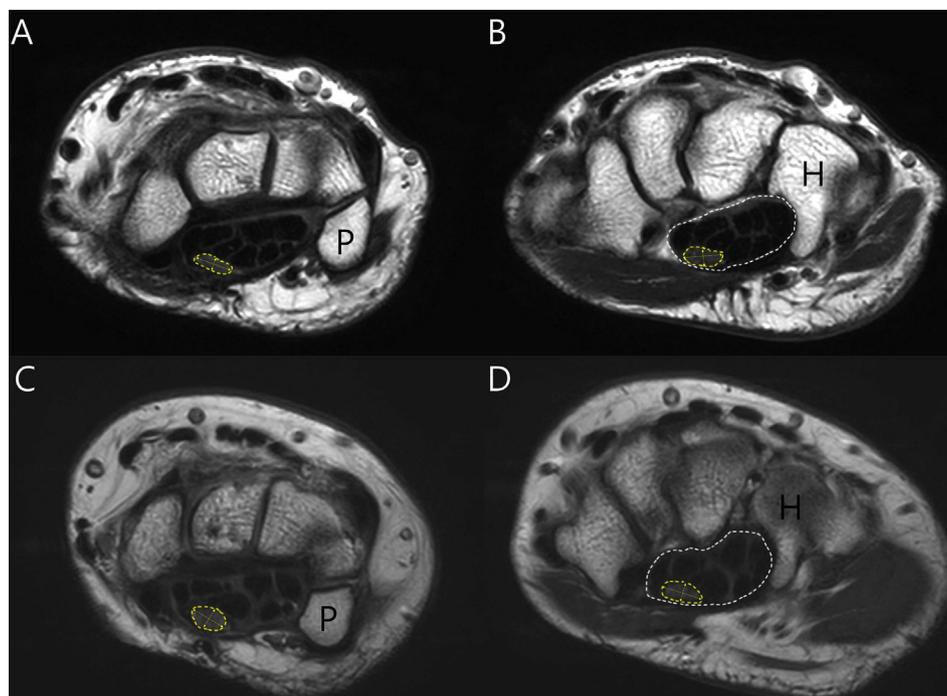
MRI axial section of the wrist (T2-weighted sequence); CTI (A), CTO (B) of control patient and CTI (C), CTO(D) of patient with carpal tunnel syndrome. The area of margination with white dotted line indicates the CSA of the entire carpal tunnel. The area of margination with yellow dotted line indicates the CSA of the median nerve. P: pisiform, H: hamate bone.
